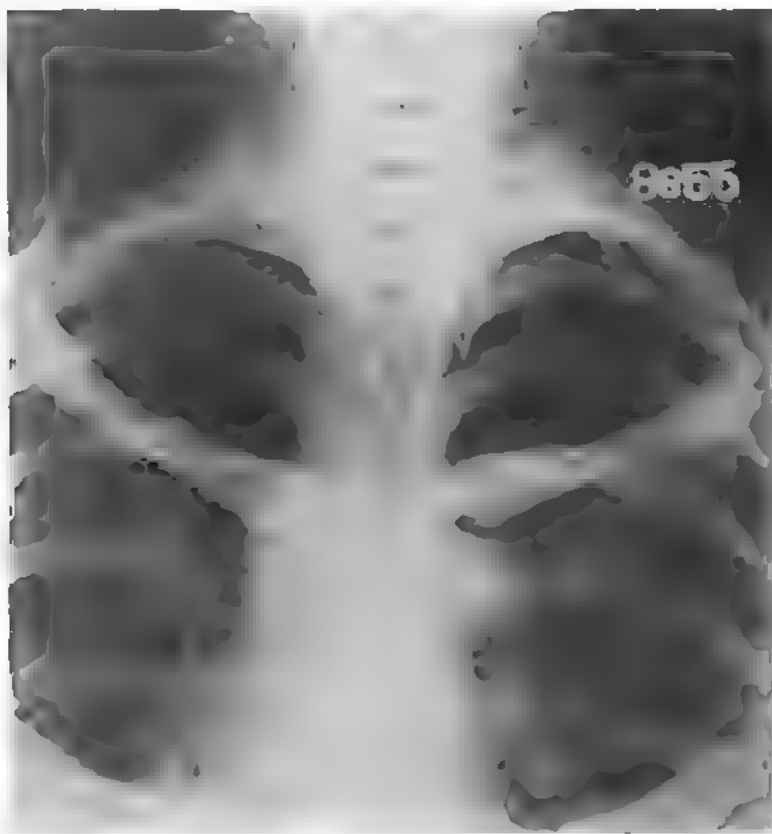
Case No. A59537. X-ray 8855. Mrs. R. F., aged thirty-two. Came for examination complaining of pelvic trouble. Examination disclosed bony prominence in both supraclavicular fossae. Neuralgic pains of an indefinite nature down the arms. X-ray showed well-marked double seventh cervical ribs. Operation not advised.
